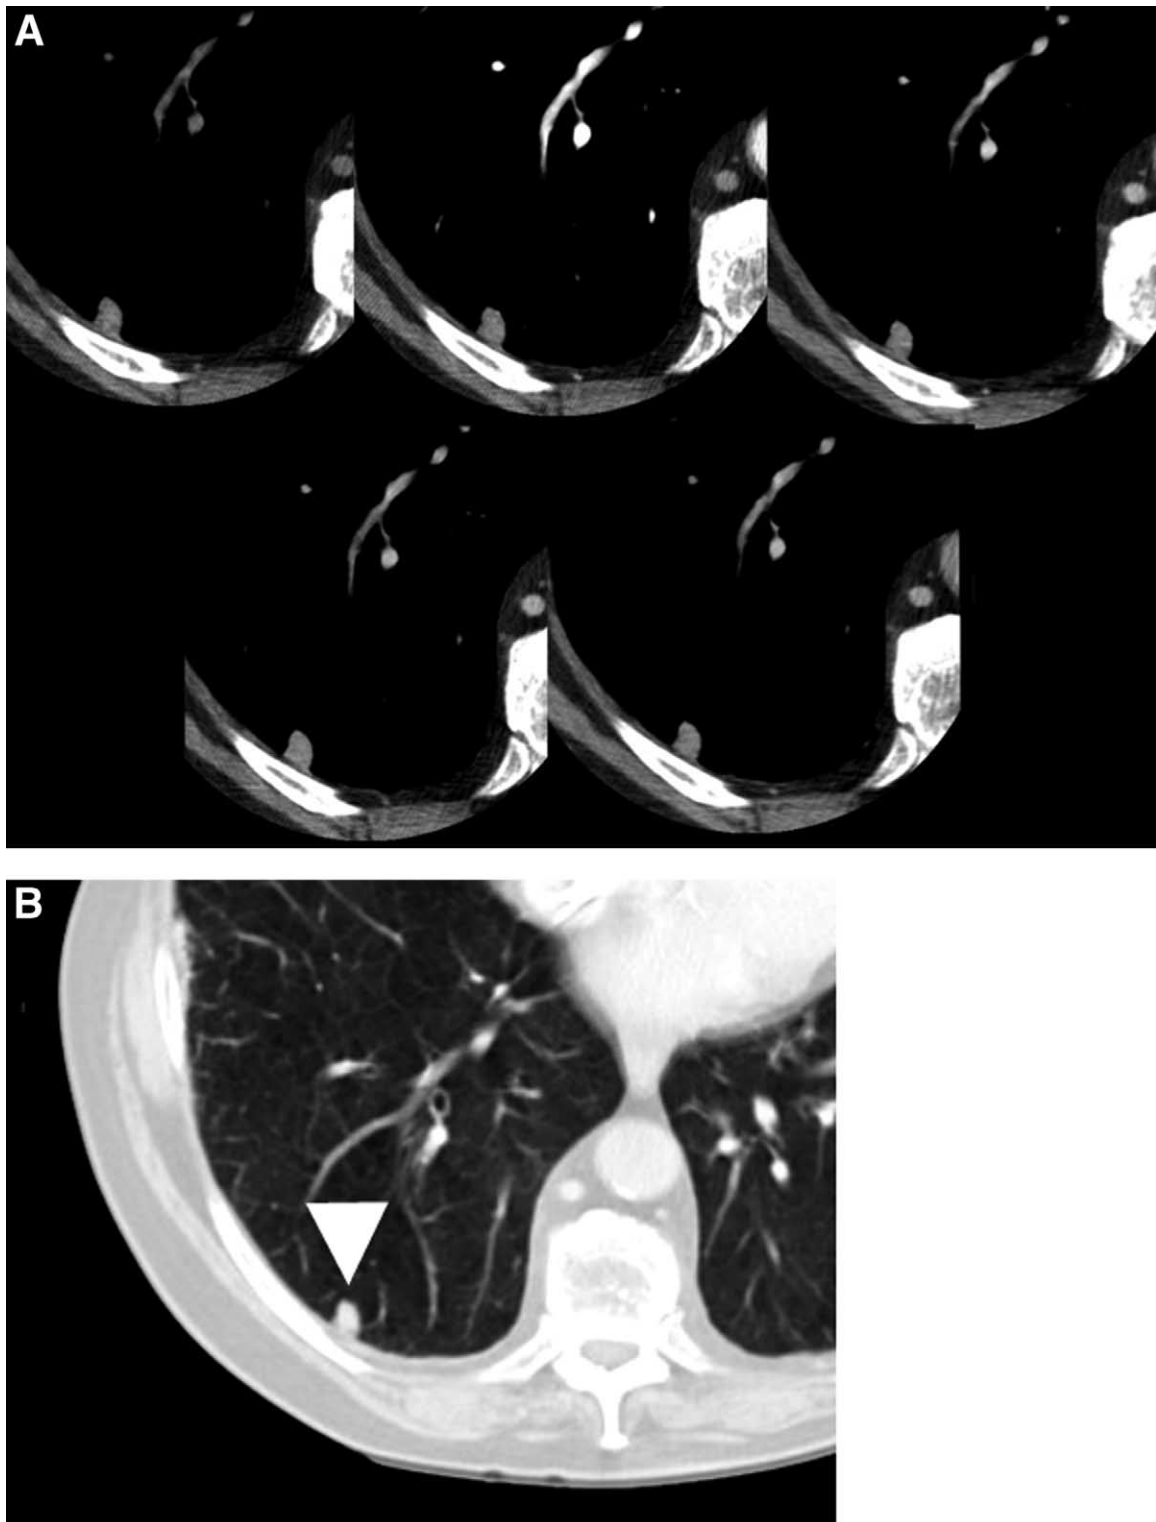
Dynamic contrast-enhanced CT: benign nodule. A 72-year-old subject with prostate carcinoma and an incidental pulmonary nodule discovered on abdominal CT examination. (A) Sequential images from a dynamic CT scan, with imaging performed precontrast, and at 1, 2, 3, and 4 min after contrast injection. The difference in density between precontrast image and the maximum enhancement image was 3 HU. (B) Axial image from a CT scan obtained 5 years later showing no change in the small right basilar pulmonary nodule (arrowhead).
